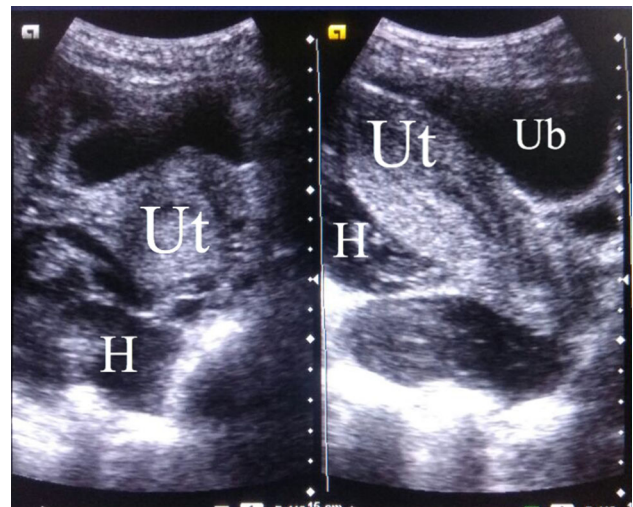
Axial sonographic image showing the normal uterine horn (Ut) and fetal head adjacent to it in the peritoneal cavity surrounded by fetal membranes with free fluid in the peritoneal cavity (H)
